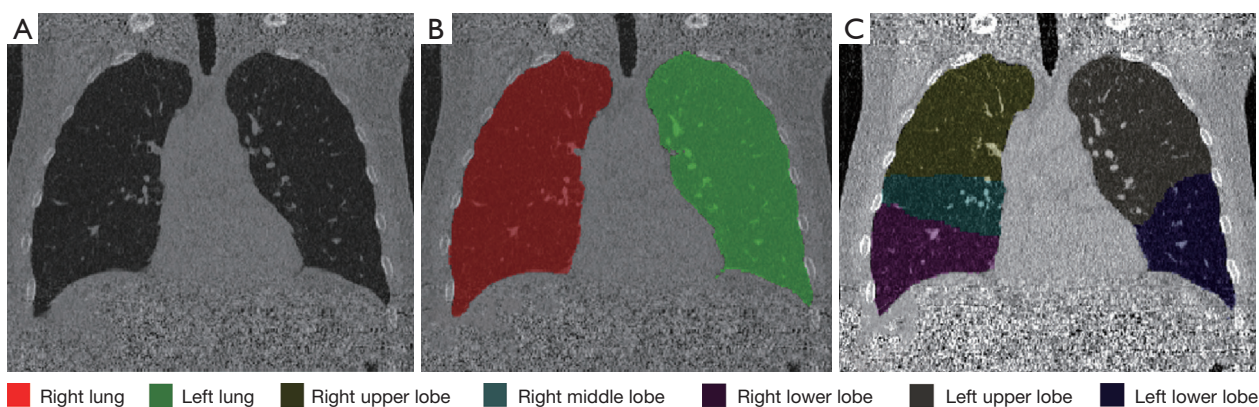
The coronal view of a patient with the CT image (A), lung masks (B), and lobe masks (C). CT, computed tomography.
